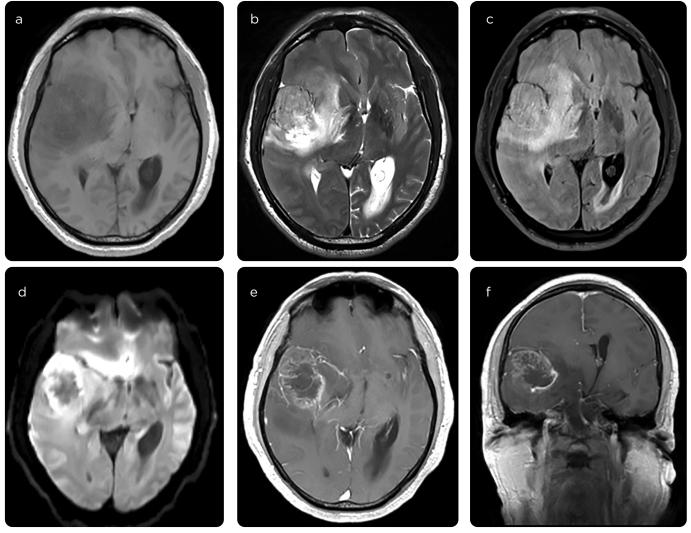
MRI of conventional brain. a) T1-weighted cross sections, b) T2, c) FLAIR sequence, d) diffusion sequence, e) T1-weighted sequence with contrast medium and f) T1-weighted coronal sequence with contrast medium: Supratentorial and intraaxial right temporal lesion, oval, 35 × 50 × 35 mm in its longitudinal, anterior-posterior and transverse axes, heterogeneous predominantly low signal in T1-weighted sequences and high signal in T2/FLAIR-weighted ones. In diffusion sequence: areas of peripheral location restriction and after administration of the peripheral enhancement contrast medium. It is associated with significant perilesional edema and mass effect on the frontal lobe, frontal shaft and body of the lateral ventricle, basal ganglia and thalamus, with contralateral midline deviation of up to 15 mm.
